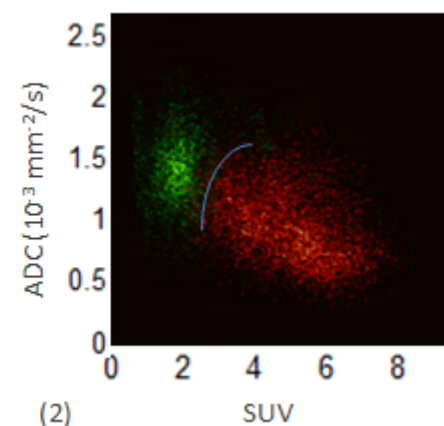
Pixelwise SUV-ADC map of all benign (green dot) and malignant lesions (red dot). The curve (blue) indicates the separation between benign and malignant lesions.
